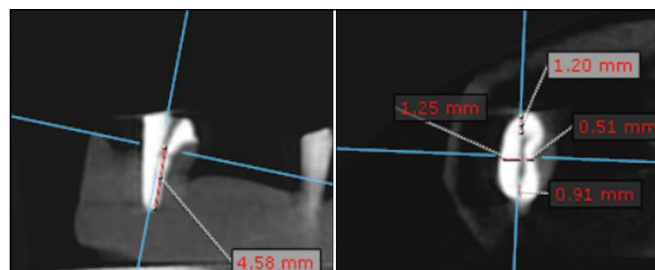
Showing CBCT image of dentin thickness measurement at 4 directions (mesial, distal, buccal, and lingual) at 4.5 mm.
